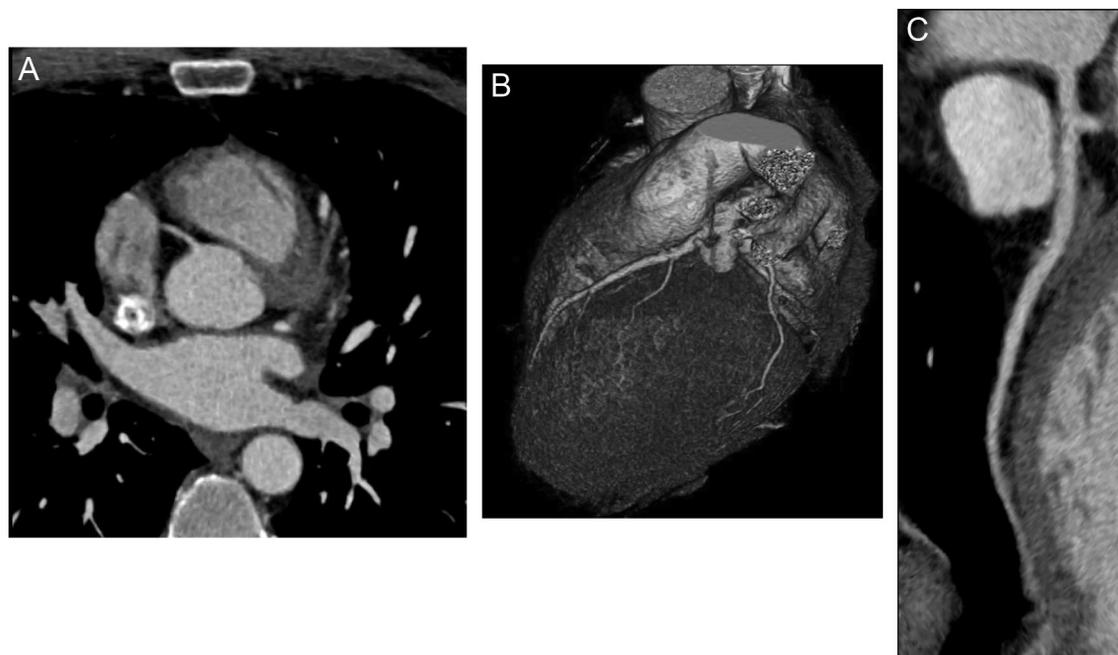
Coronary CTA with iodixanol 320 (80 mL, 5 mL/s) of a 45-year-old man (BMI, 25.7 kg/m²) with only moderate coronary arterial enhancement (mean, 310–322 HU), and good quality scores (4 of 5, for all 3 readers) for vessel visualization and diagnostic confidence. Of 17 vessel segments the readers assessed only 14, 10, or 13, respectively, as adequately delineated. A, axial slice; B, VR image; C, curved multiplanar reformat of the LAD artery.
